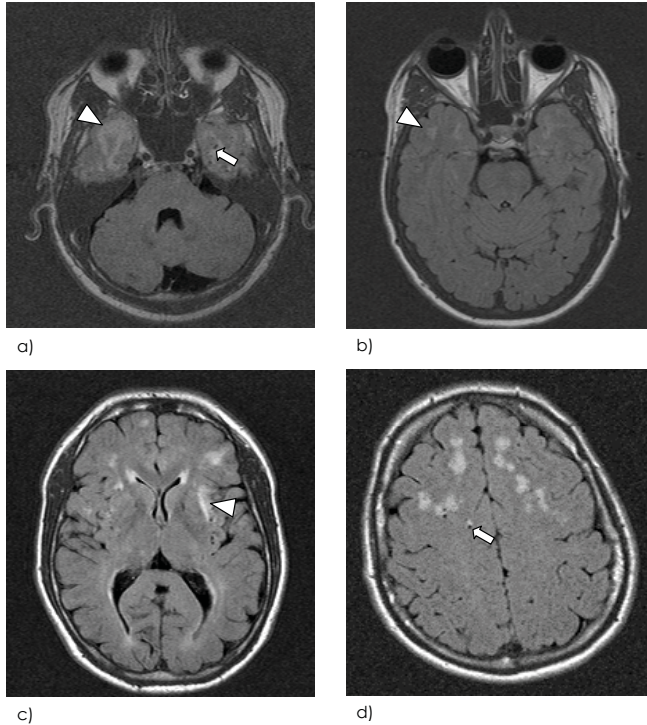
Axial FLAIR MR images obtained in NOTCH3 mutation carriers who were 31-40 years old. At this age, areas of hyperintensity (arrowhead in a and b) and SLLs (arrow in a) expand from the anterior temporal lobe posteriorly and affect the whole temporal lobe. Areas of hyperintensity in the semiovale centre become larger. Areas of hyperintensity in the external capsule (arrowhead in c) and lacunar infarcts (arrow in d) are present.
